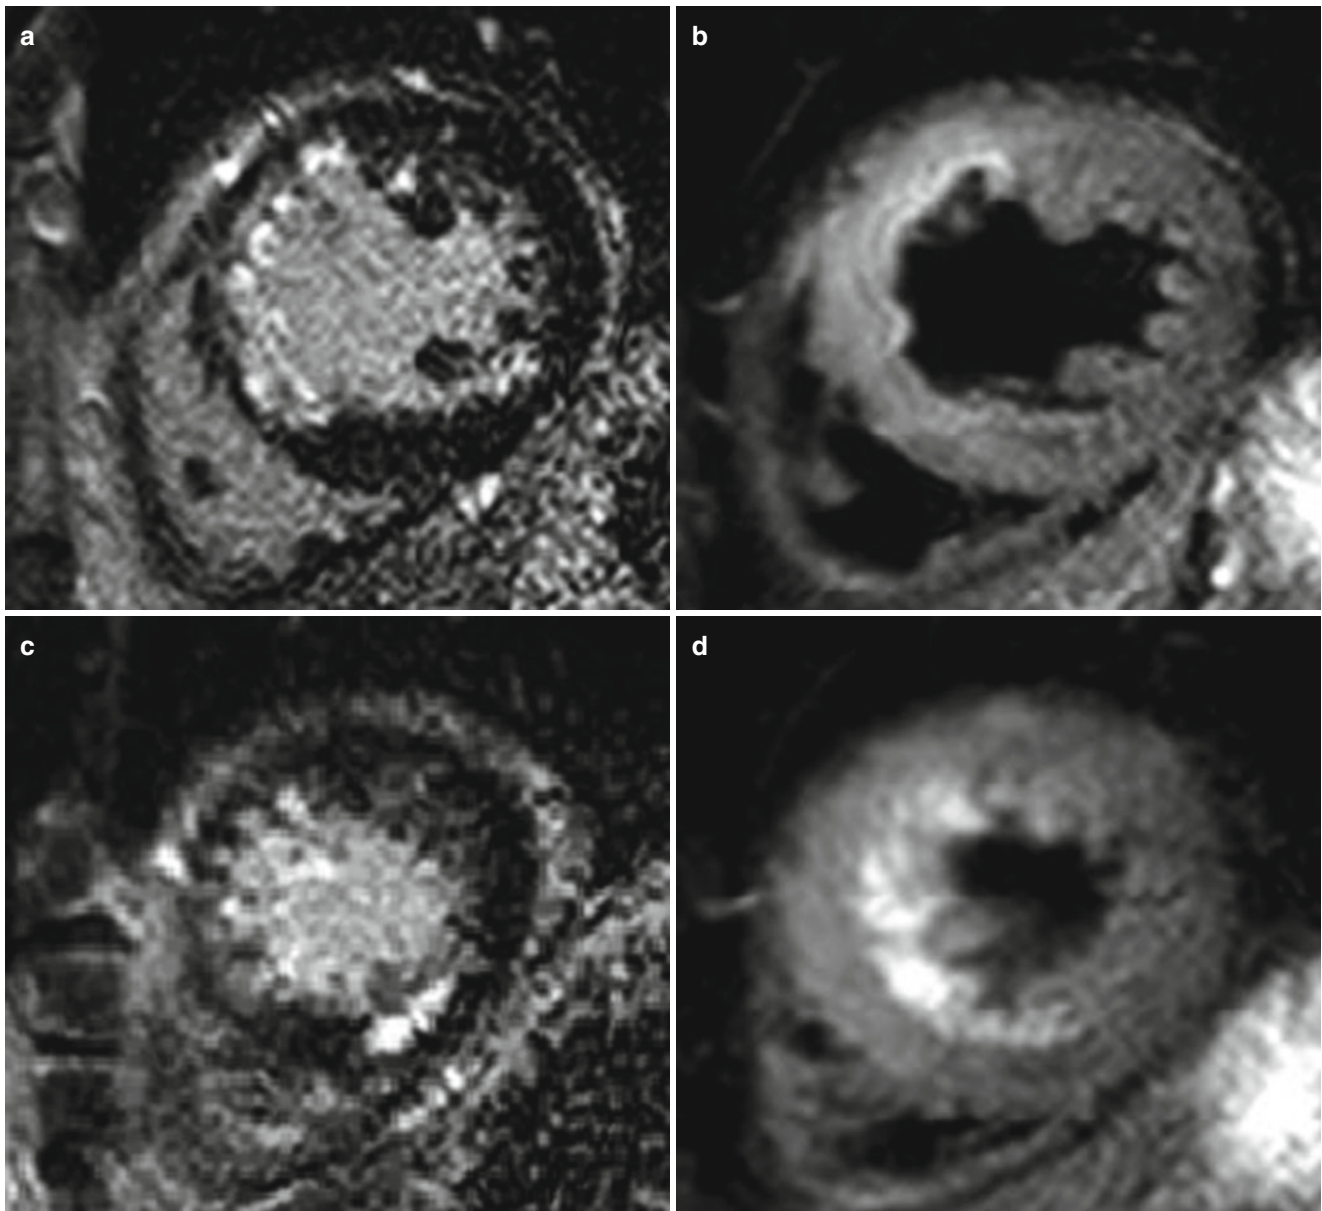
The role of T2WI and LGE in diagnosis of coexisting acute and chronic MI. A 45-year-old male with acute chest pain examined with cardiac MRI. Hyperenhancement at the apical septal and mid-anteroseptal wall with hyperintensity on T2WI, suggestive of acute MI
